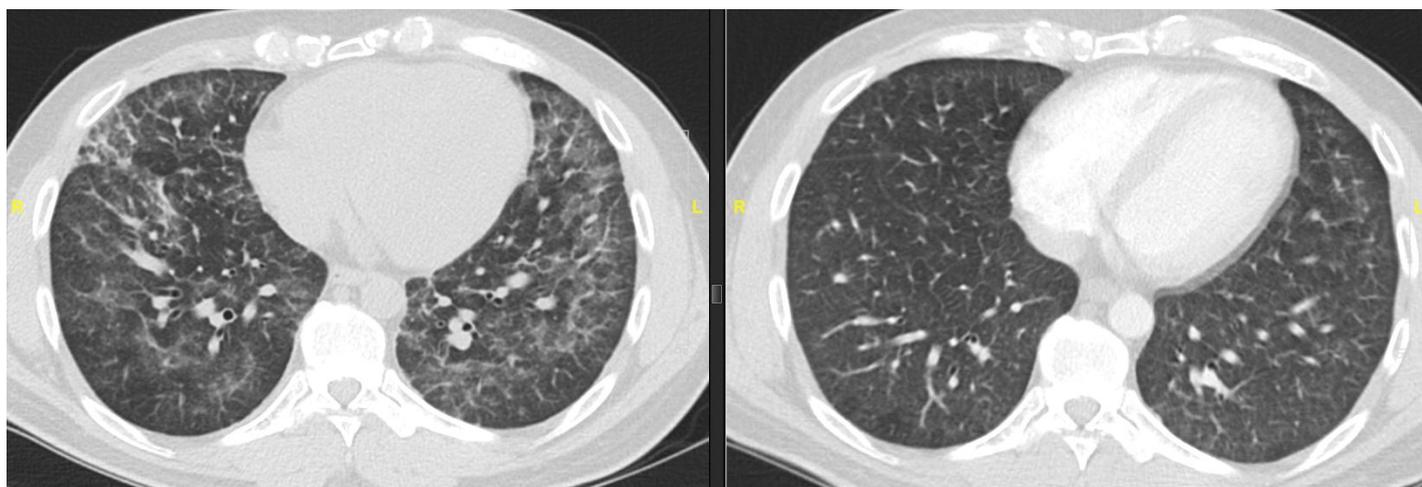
Left – CT chest image with diffuse ground glass and consolidative opacities. Right – CT chest image performed one week later with improvement to diffuse ground glass and consolidative opacities
